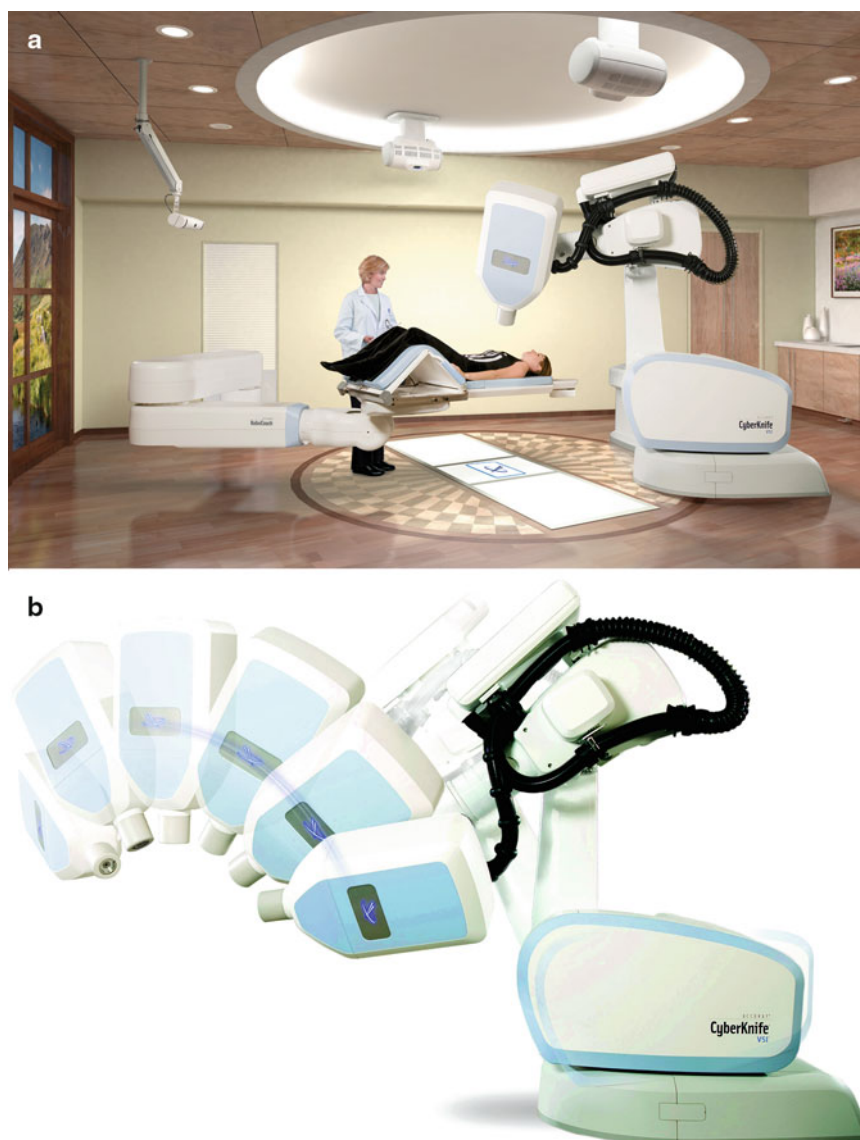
The CyberKnife system consists of a small 6-MV linac mounted on a computer-controlled robotic arm capable of moving with 6° of freedom, two orthogonally placed X-ray, two optical cameras, and an optic-radiographic motion monitoring system for real-time tumor tracking. Radio-opaque fiducial markers implanted in or near the tumor and light-emitting diodes placed on the patient's chest are used for target tracking. Prior to radiation treatment and while the X-ray beam is off, a series of X-ray images are taken by the two orthogonal cameras at various times during the respiratory cycle and the system develops a mathematical model relating the locations of the light-emitting diodes on the chest with those of the fiducials near the tumor in the lung.
